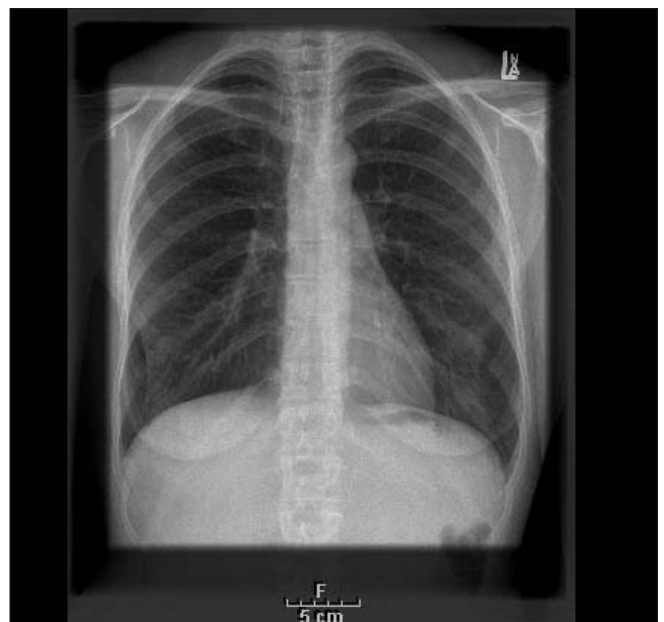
Results of chest x-ray taken 5 days after the incident.
